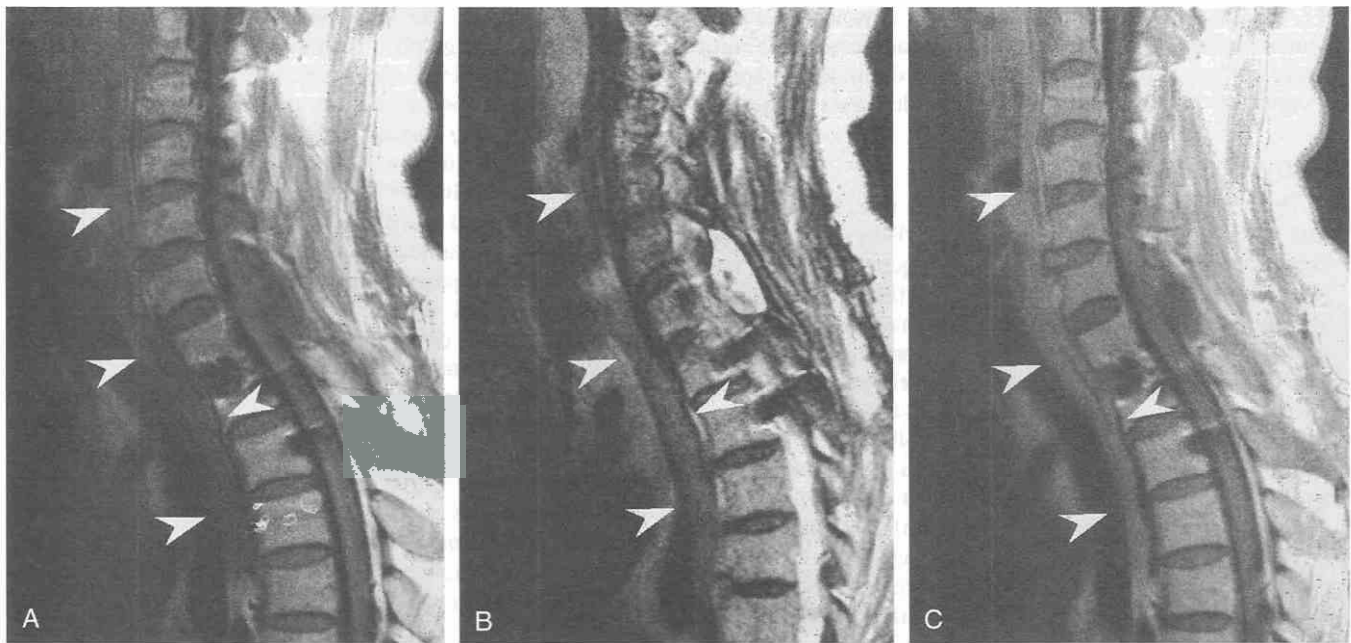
MR images of normal esophagus. *A*, On the T1-weighted image, the signal intensity of normal esophageal wall (arrowheads) is low. *B*, On the T2-weighted image, the signal intensity of the esophageal wall (arrowheads) is also low, contrasted with internal contents of high signal intensity. *C*, After administration of gadolinium-DTPA, esophageal wall (arrowheads) shows moderate enhancement.
